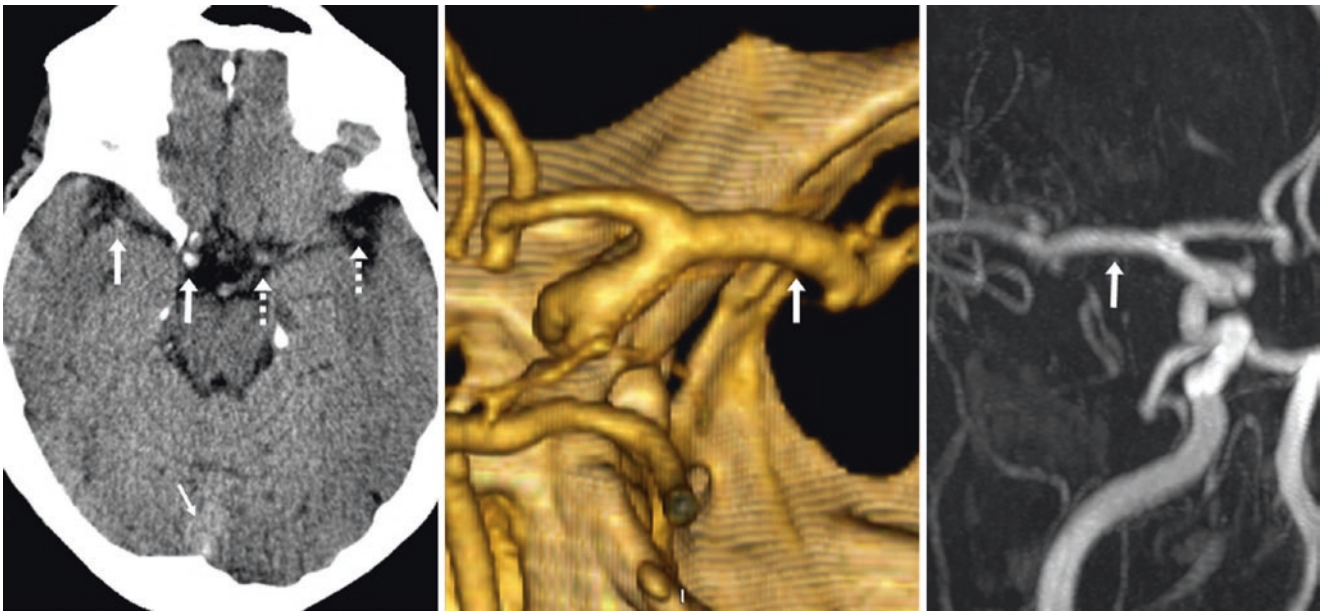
79-year-old with a dense MCA. The patient had stroke-like symptoms, and a dense right middle cerebral artery (MCA) was questioned (*arrows*) on nonenhanced CT (NECT) (*left*), as compared with contralaterally (*dotted arrows*), owing to either beam hardening or
